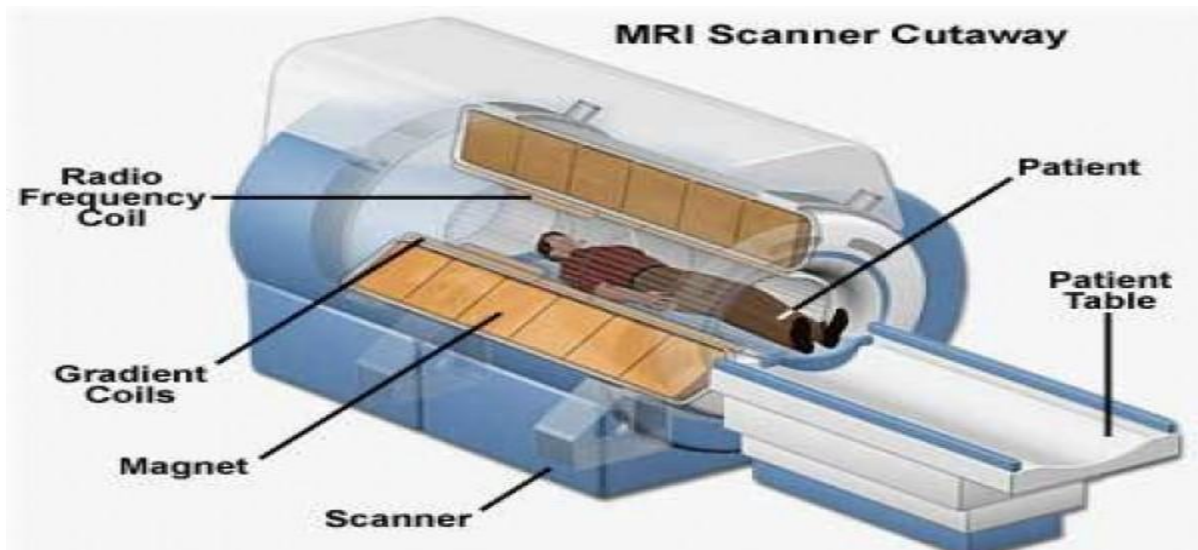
MRI scanner [9]
